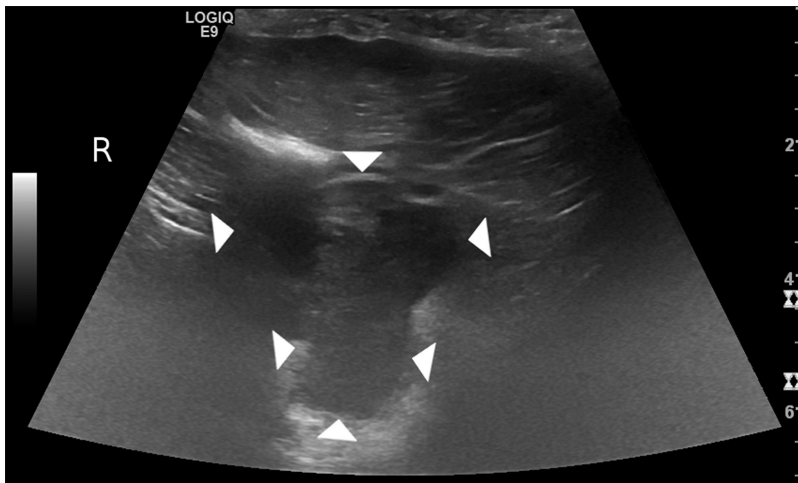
Transverse plane ultrasonographic image at the level of the renal mass of the chicken in Figure 1. A lobulated, hypoechoic mass (arrowheads) is visible with hyperechoic adjacent mesentery. Dorsal is at the top of the image. Image was obtained via a transcoelomic approach with a 15-MHz linear transducer.
